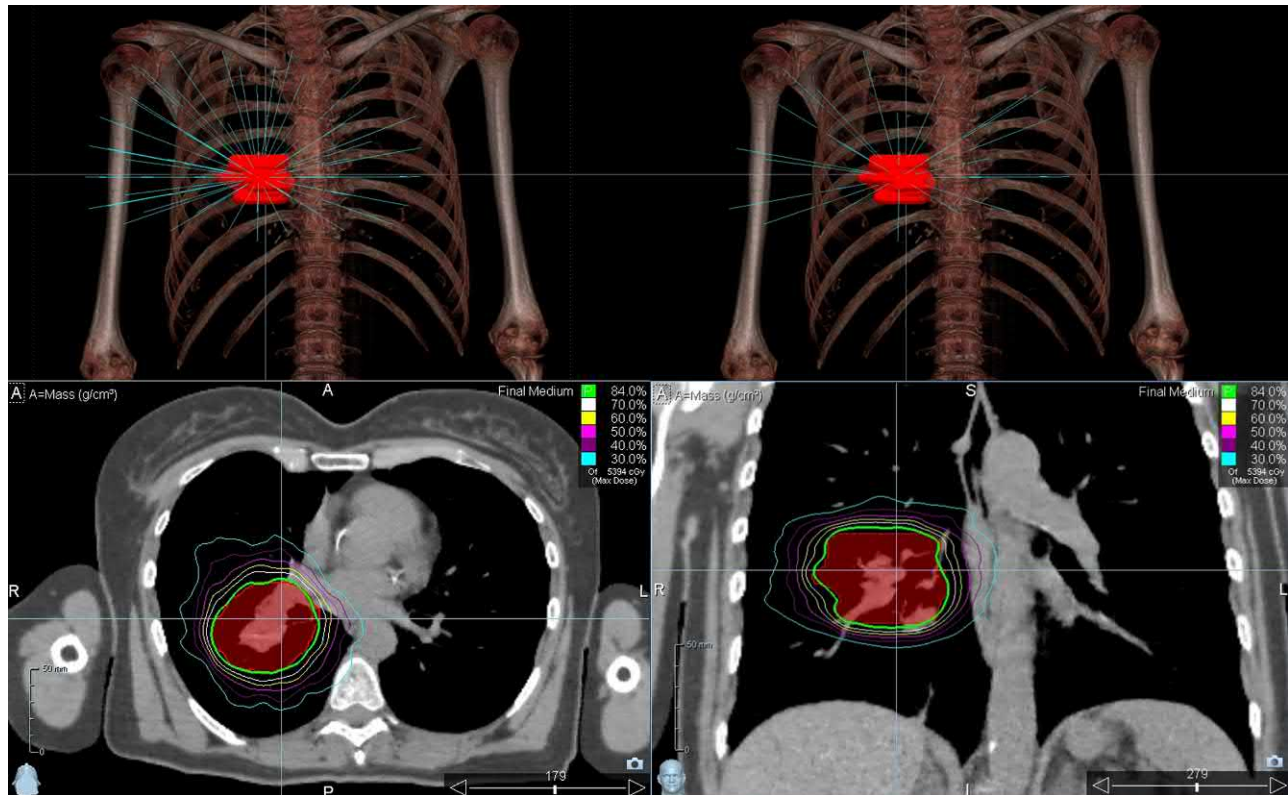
An example treatment plan for a lesion in the right lung. Top-left shows an anterior view of the 3D patient model (for simplicity the tissue density has been windowed to show only bone, and the only segmented structure is the PTV, shown in red). The *blue lines* show 100 noncoplanar beam directions that are available to treat this target. Each line corresponds to a position and orientation of the treatment robot relative to the patient that does not violate robot joint, cable management, or collision constraints. Top-right shows the subset of 24 beams which in this case were selected during the treatment plan optimization. The bottom panels show axial and coronal sections of the CT scan. The dose distribution resulting from the optimized set of beam directions and beam fluence is shown by the *colored isodose lines* (connecting points of constant dose). In this case the conformality of the treated volume (within the green line) to the PTV is high, as is the dose fall-off in all directions (shown by the closely spaced *isodose lines* outside the PTV). These are among the dose representations that the treating physician will typically review before approving the plan for treatment. *3D*, Three-dimensional; *PTV*, planning target volume.
